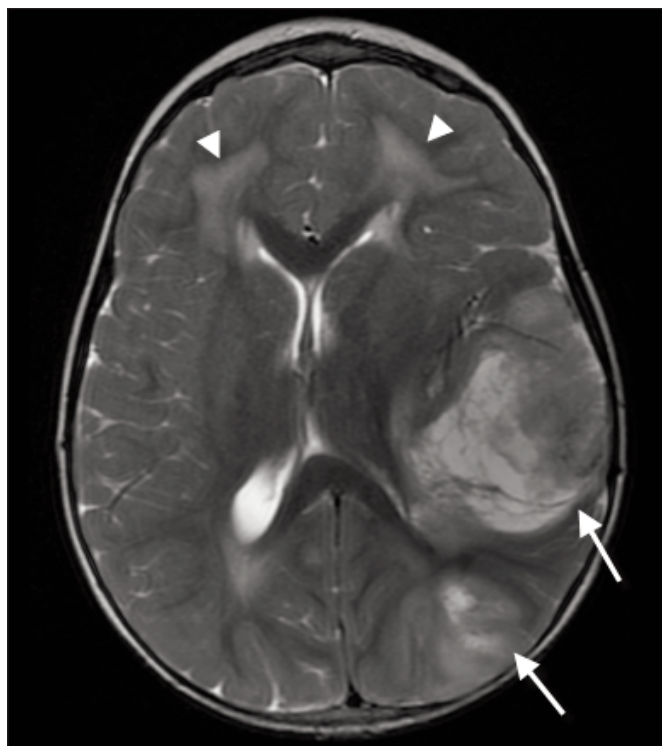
Patient 1: Axial T2-weighted MRI at level of basal ganglia showing multifocal PNET (arrows) and white matter injury from previous chemotherapy and radiotherapy (arrowheads).
